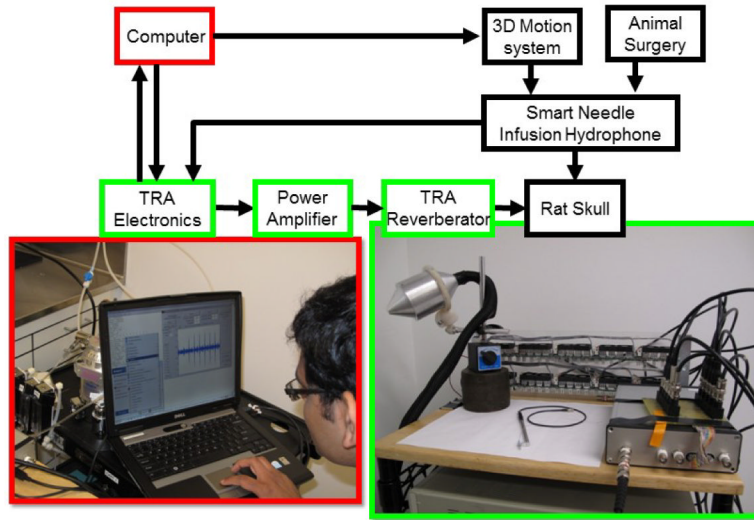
Time-Reversal Acoustics Ultrasound-assisted Convection Enhanced Delivery (TRA-UCED) system.
